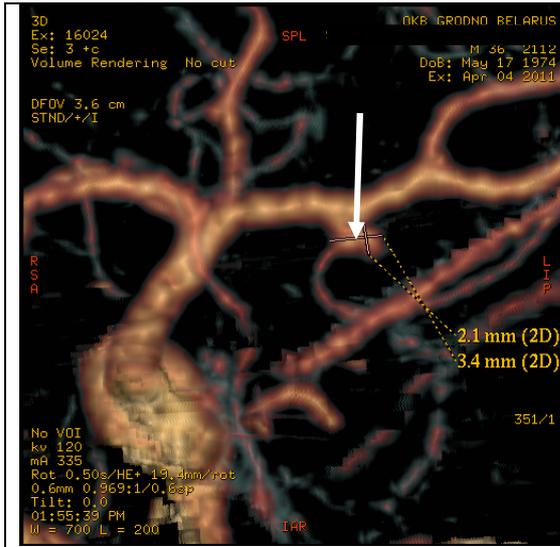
3 D spiral CT. Aneurism at posterior brain artery (arrow).
